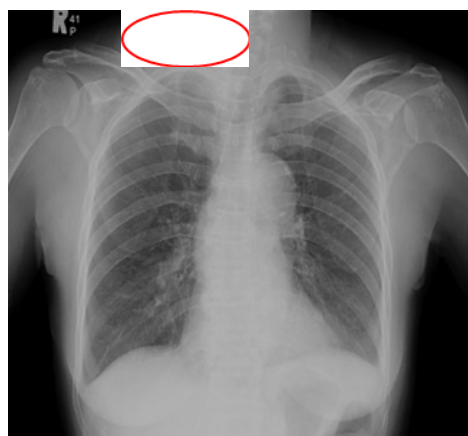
Chest X-Ray Showed Opacity with Indistinct Borders on The Right Neck Soft Tissue (Red Circle)
